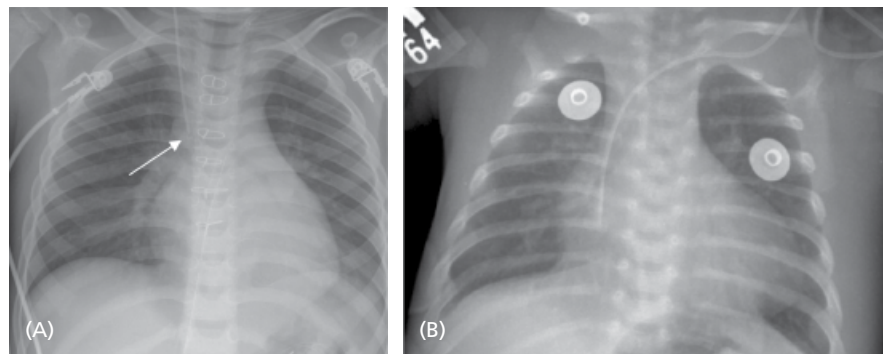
(A) Postoperative chest radiograph with the tip of a right internal jugular vein catheter in proper position in the mid superior vena cava. (B) Tip of catheter malpositioned, deep in the right atrium.
